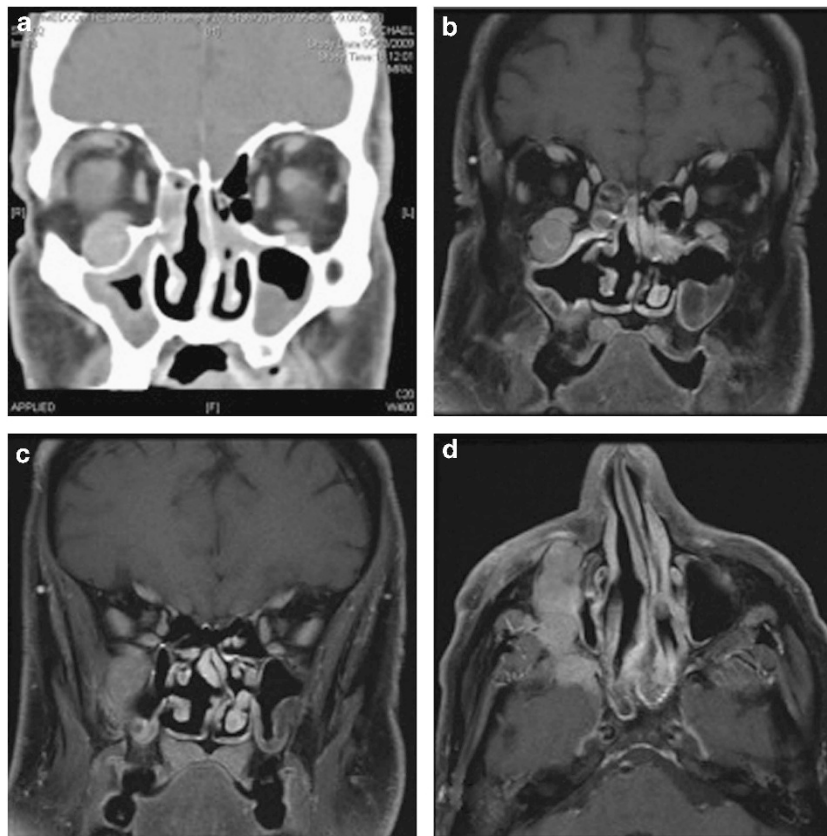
(a) Coronal CT scan and (b) T1-weighted coronal MRI scan demonstrating enlargement of the right infraorbital nerve, abutting the inferior rectus, with expansion of the infraorbital canal, and (c) extension into the pterygopalatine fossa. (d) The gross enlargement of the right infraorbital nerve is seen along its entire course on axial MRI.
